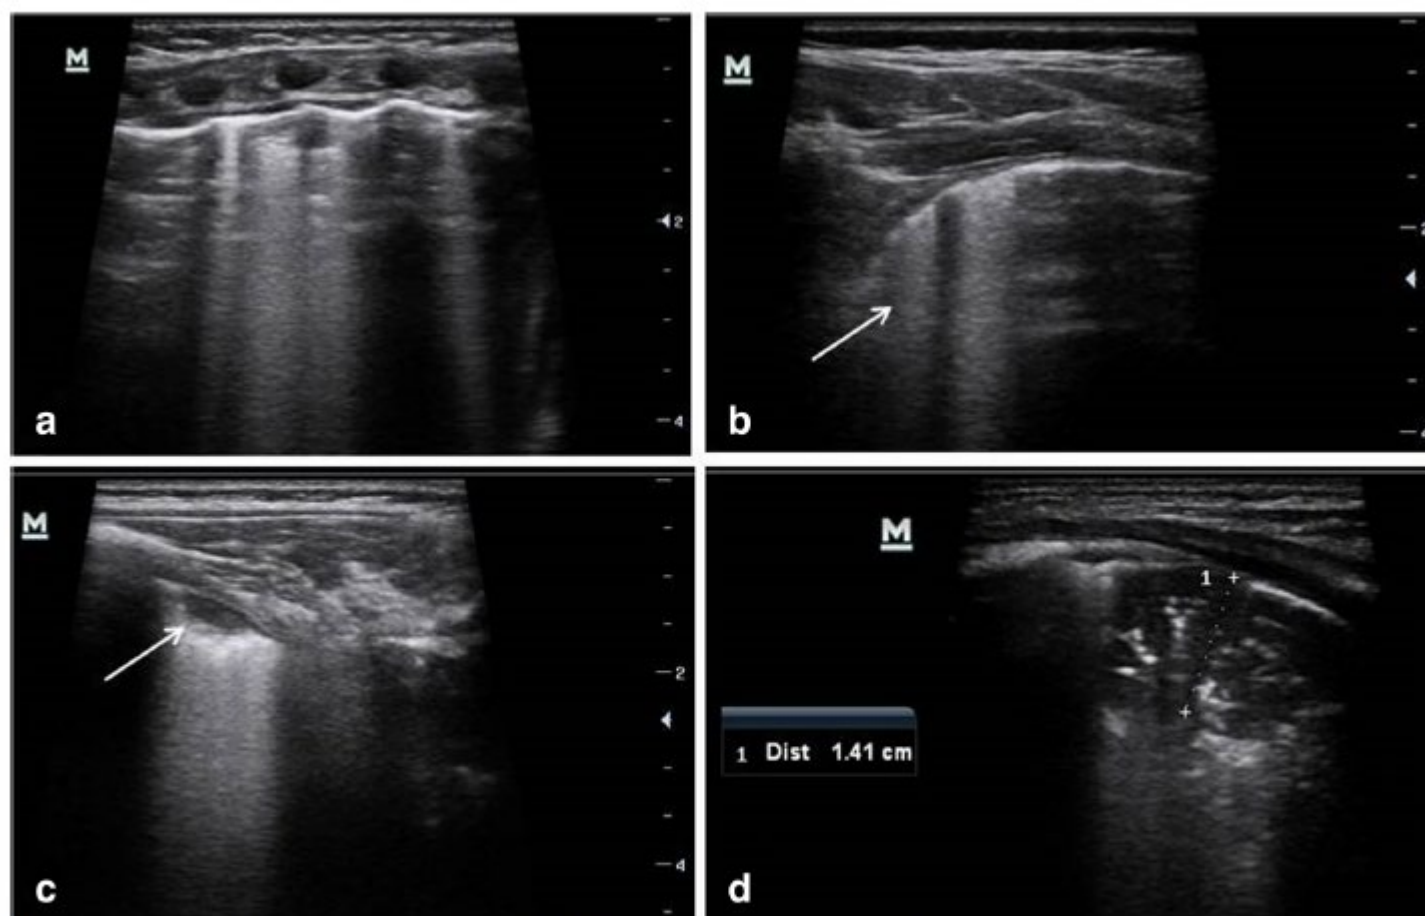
Lung ultrasound images in a patient with bronchiolitis complicated by pneumonia. a Transversal intercostals approach showed multiple B lines, consistent with bronchiolitis. b Longitudinal thoracic scan, revealed irregular pleural surface and confluent B lines (arrow). c The left posterior lung field showed a small subpleural consolidation without sonographic air bronchograms (arrow) - a typical finding in infants with bronchiolitis - associated with focally confluent B lines arising from the margin of the consolidation. d The scan of the posterior region of the right lung revealed a consolidation with hyperechoic air bronchograms suggestive of pneumonia
